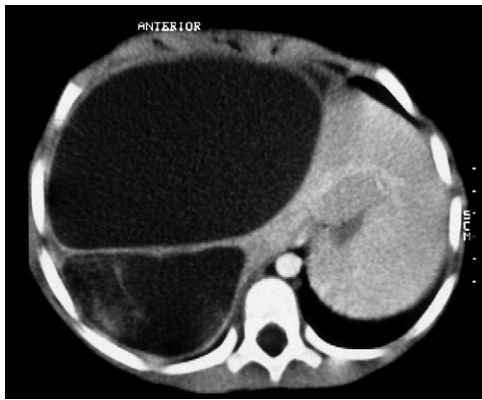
Abdominal CT scan of a 7 year-old girl with an MHL consisting predominantly of 2 large cysts.
